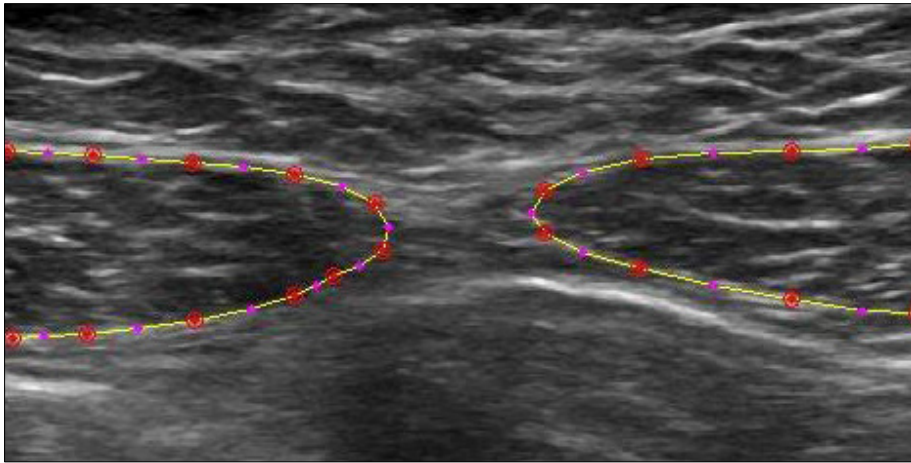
Rectus abdominis ultrasound image. Points digitalized by the examiner on the muscles contour (red dots).
